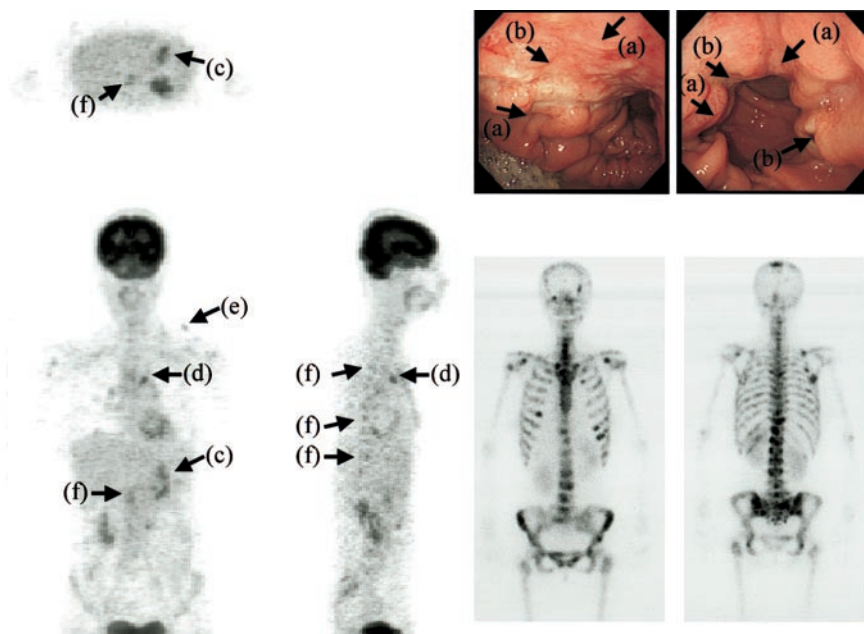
Borrmann type V lesions with multiple bone metastases. On endoscopic images, primary lesion is shown as scirrhous infiltration (arrows, a) accompanying some ulcerated areas (arrows, b). ^{18}F -FDG demonstrates hot foci (arrows, c) corresponding to ulcerated areas. On images of bone scintigraphy, there are many hot spots corresponding to metastases on skull, scapula, vertebrae, costae, and sternum, but ^{18}F -FDG PET image suggests bone metastases only in sternum (arrows, d) and part of scapula (arrow, e) and vertebrae (arrows, f).
